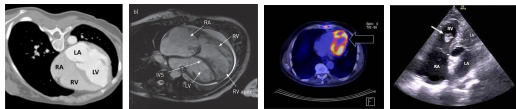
Four types of Cardiac Imaging. From left to right: Computerized Tomography (CT), Magnetic Resonance Imaging (MRI), Positron Emission Tomography (PET), and Ultrasound (US).[MRI,]
